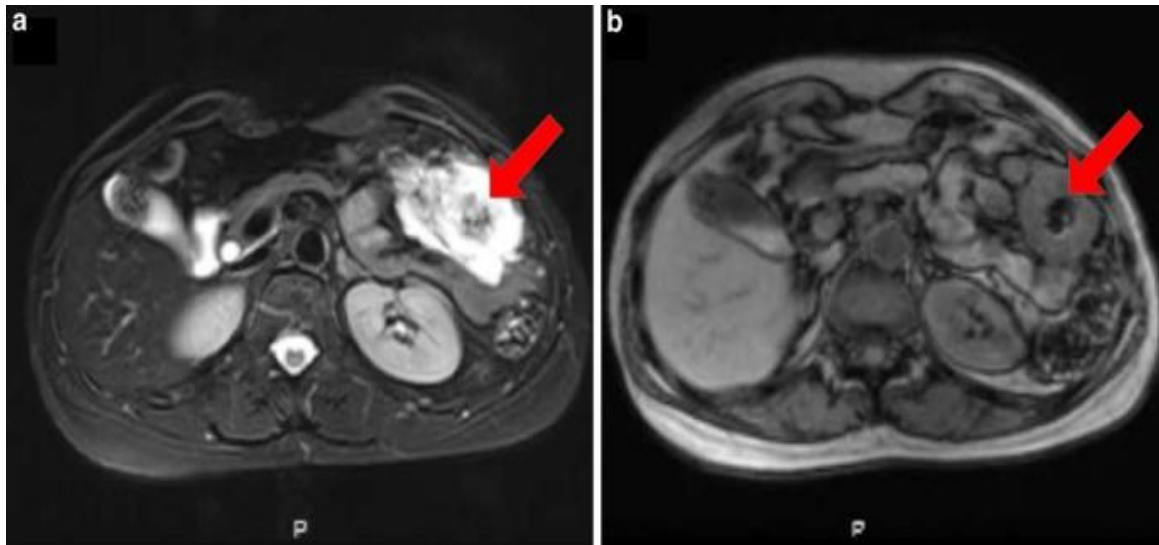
Left to right, T2 and T3 magnetic resonance images, respectively.
